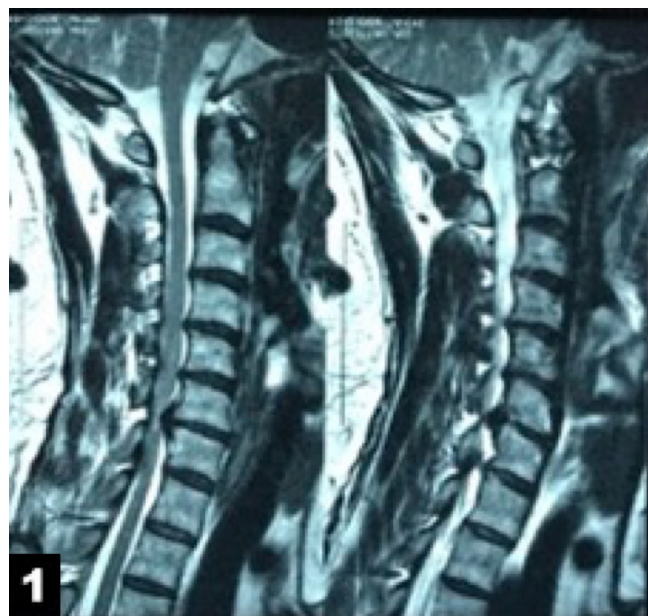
Cervical T2-weighted sagittal MRI showing C6-C7 protruded disk and multilevel spondylosis, Note the congenital narrow canal
